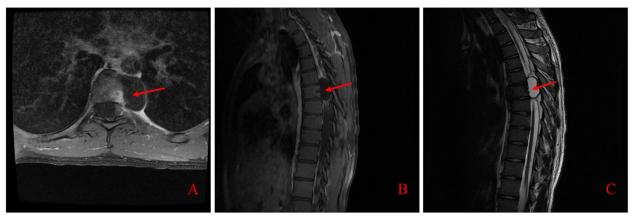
Coronal and Sagittal MRI images of the spine. A Coronal T1-weighted MRI image (red arrow). B Sagittal T1-weighted MRI image (red arrow). C Sagittal T2-weighted MRI image (red arrow)
